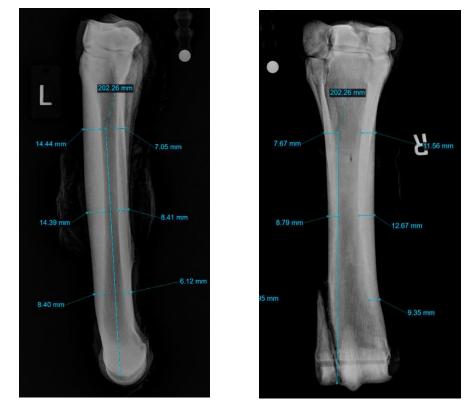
Cortical thickness measurements taken where possible at 25%, 50%, and 75% lengths from x-ray images taken from medial-lateral (left) and anterior-posterior (right) views. 10mm scale ball and left/right markers can also be seen. The annotation running down the length of the bone, shown here at the 25% position, was used to visualize where to take cortical thickness measurements.
